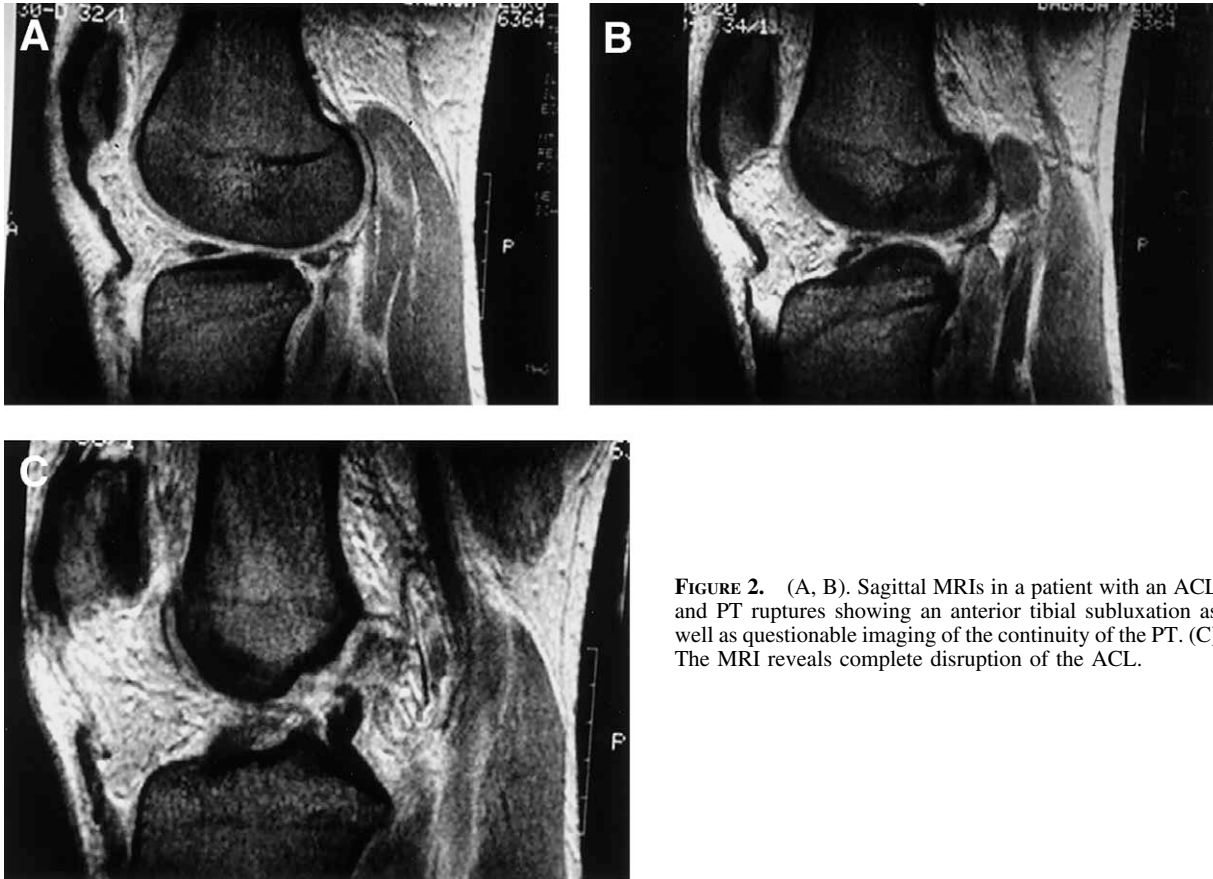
(A, B). Sagittal MRIs in a patient with an ACL and PT ruptures showing an anterior tibial subluxation as well as questionable imaging of the continuity of the PT. (C) The MRI reveals complete disruption of the ACL.
